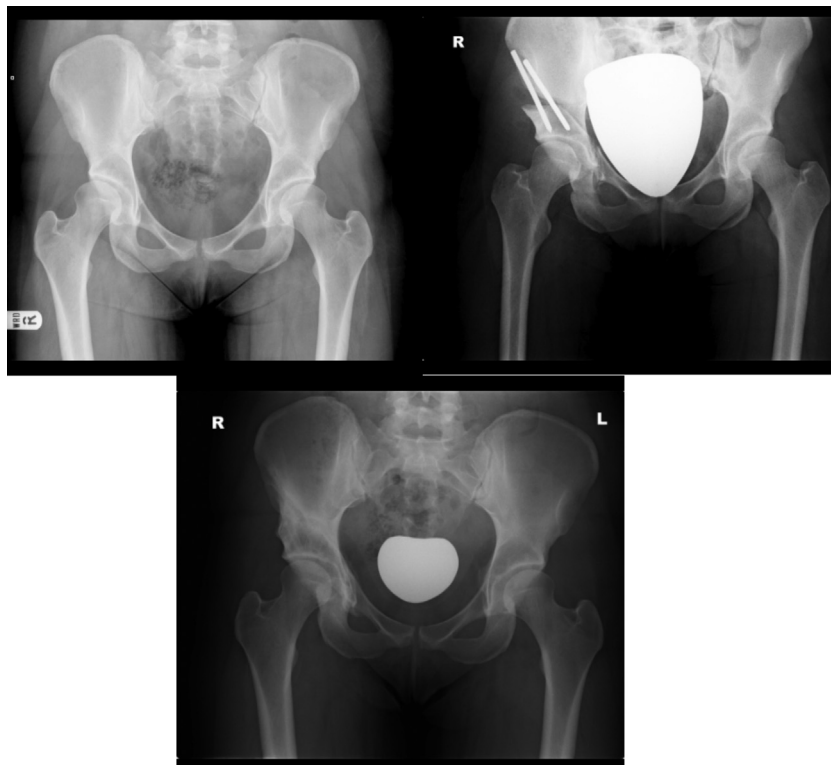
Peri-acetabular osteotomy of the left hip (preoperative, postoperative and long-term radiographs).
